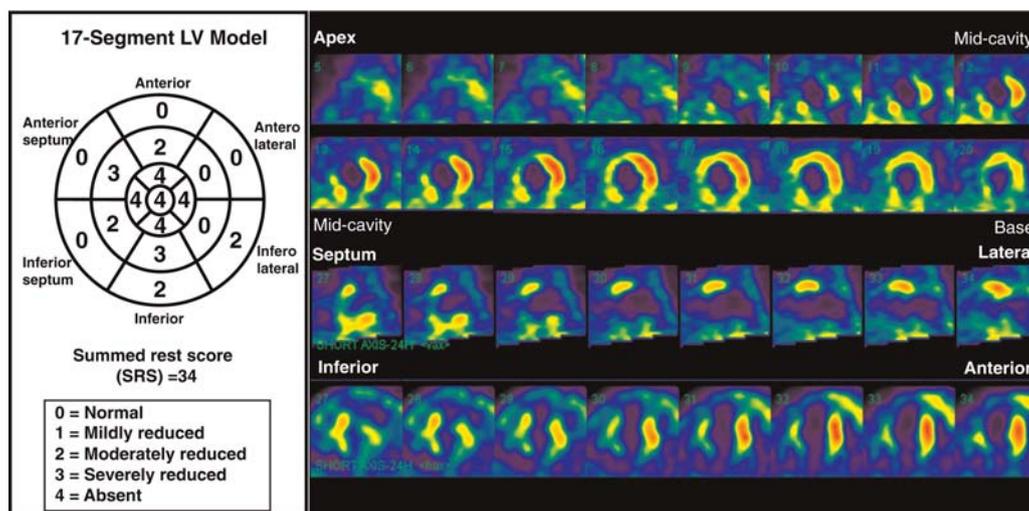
A representative 24 h redistribution Tl^{201} single-photon emission computed tomography scan from an ischaemic cardiomyopathy patient with high scar burden (SRS = 32) who underwent cardiac resynchronization therapy and had a poor outcome. The short-axis (upper two rows), vertical long-axis (third row), and horizontal long-axis slices (bottom row) show extensive perfusion defects in multiple vascular territories. The summed rest score was derived using a standard 17-segment left ventricular model and semi-quantitative perfusion score shown in the left panel.
